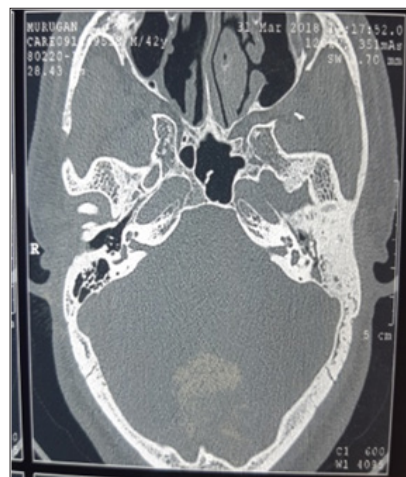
HRCT Temporal Bone Scan Imaging revealing Soft Tissue in Left Epitympanum and Mesotympanum extending to Mastoid Air Cells and Erosion of Long Process of Incus. No evidence of Facial Canal or Lateral Semicircular Canal Involvement
